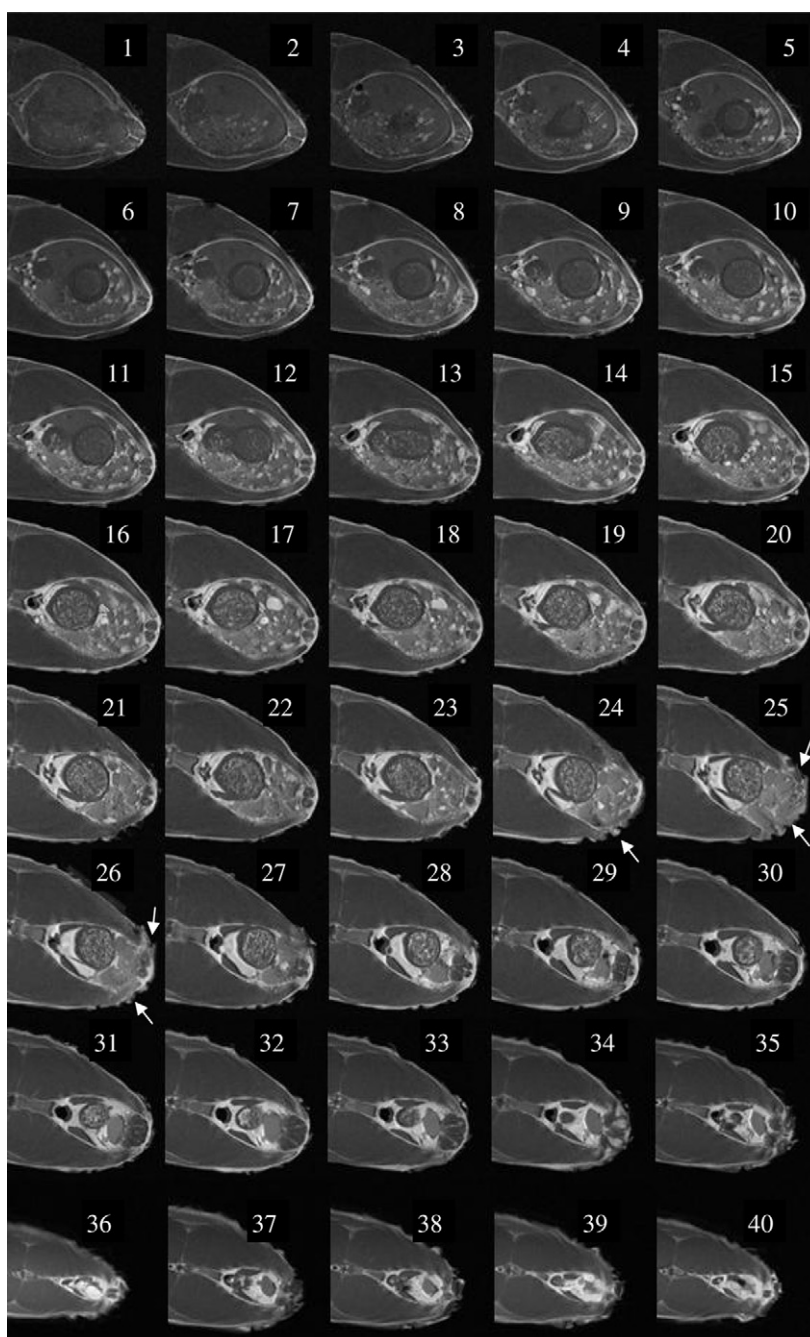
MR images of all slices at the beginning of the MRI examination. Slice number 1 is closest to the head. The herring had been frozen immediately after capture. Damaged parts of the skin in slices 24–26 are indicated with arrows.
